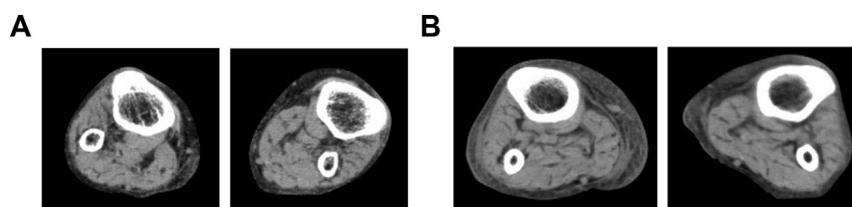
Reticular patterns in the soft tissues indicated necrotizing fasciitis. A. Lower extremity CT scan on admission. B. Lower extremity CT scan on day 7.
